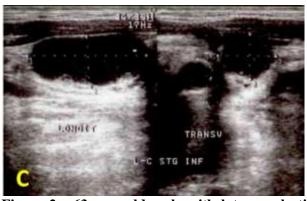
63-year old male with late anaplastic shift from papillary thyroid cancer; 5 months after subtotal thyroidectomy the tumour aggressively extended. Thyroid ultrasound shows
